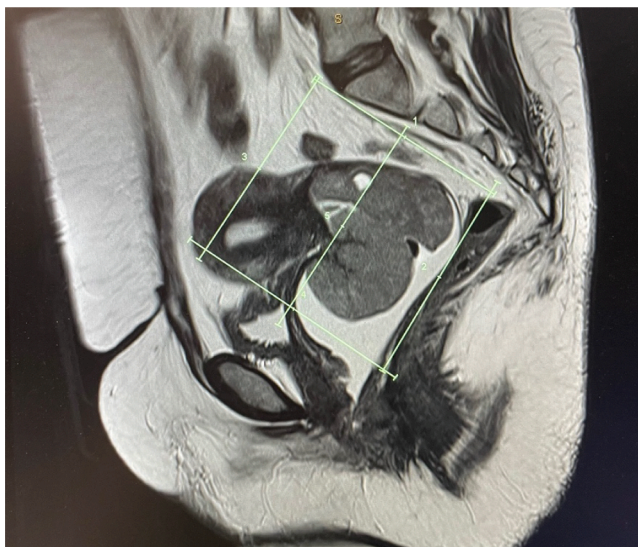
Magnetic resonance imaging of the invasive cervical carcinoma.
